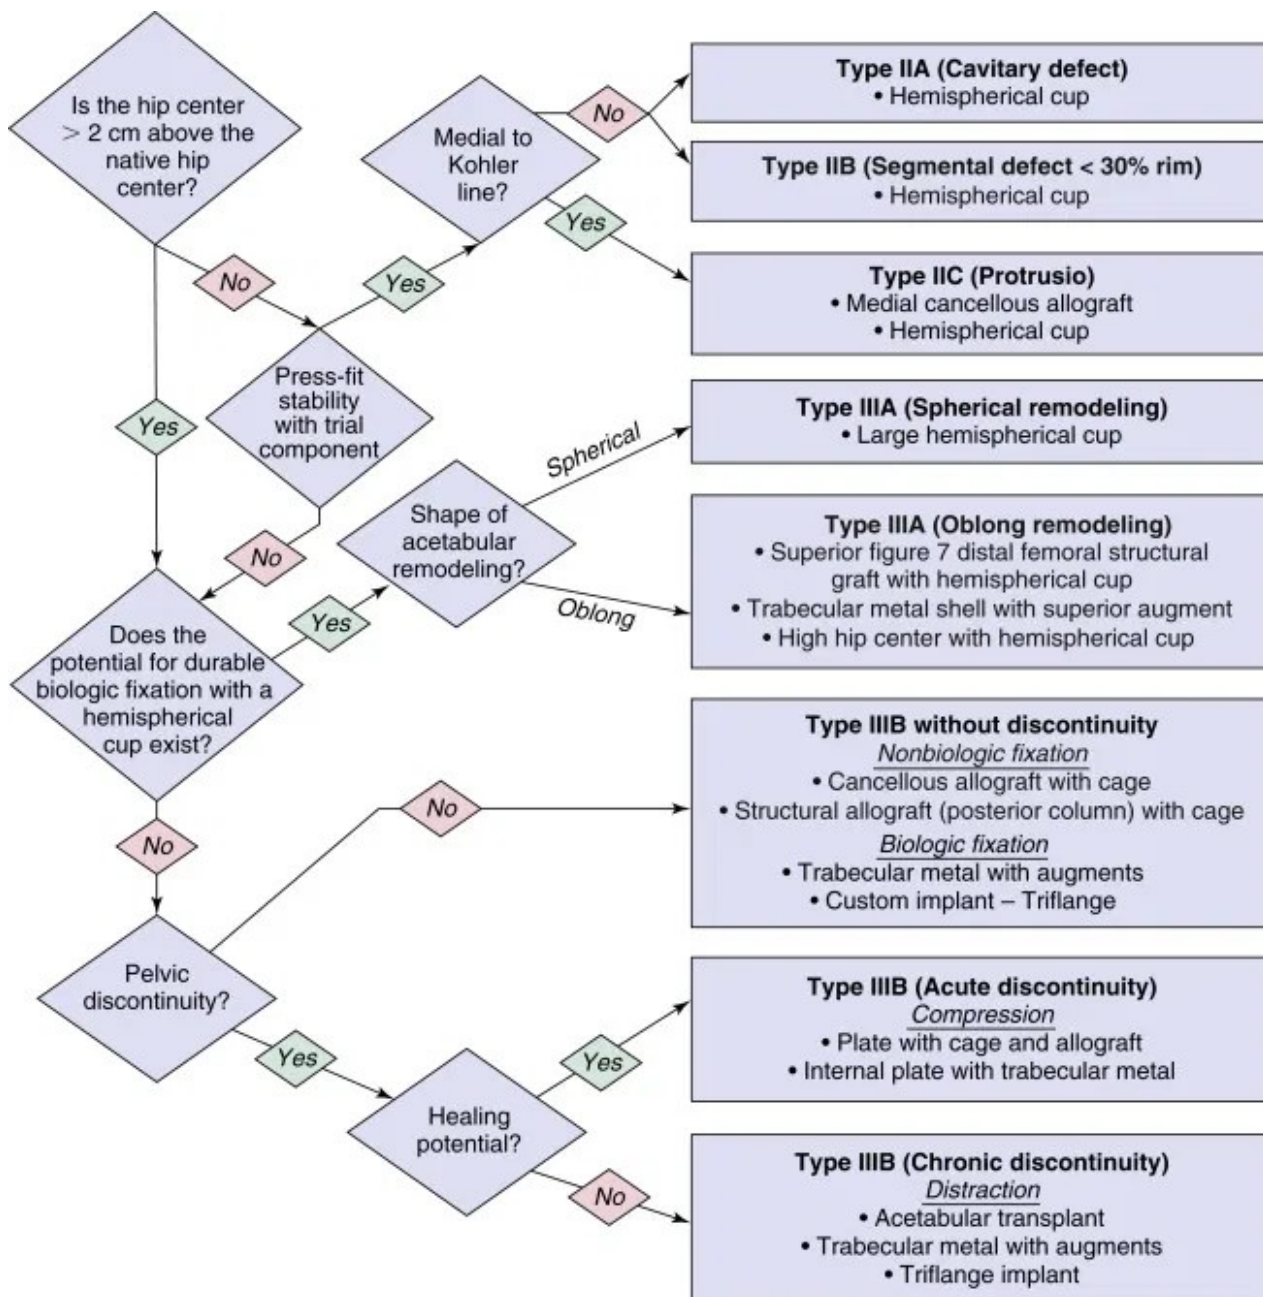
Algorithm for acetabular revision based on periacetabular bone defects (CT-ARA)
